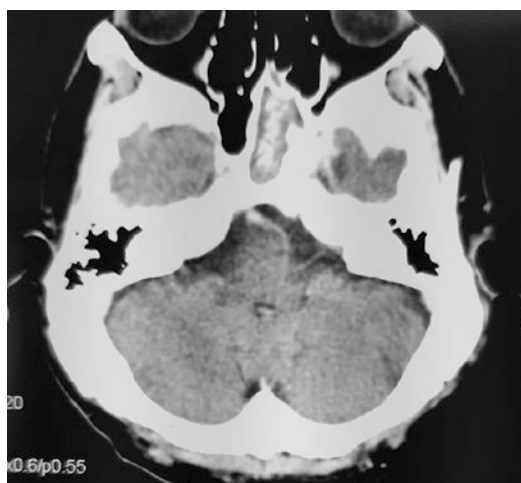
CT sinuses demonstrating complete opacification of the left sphenoid sinus
